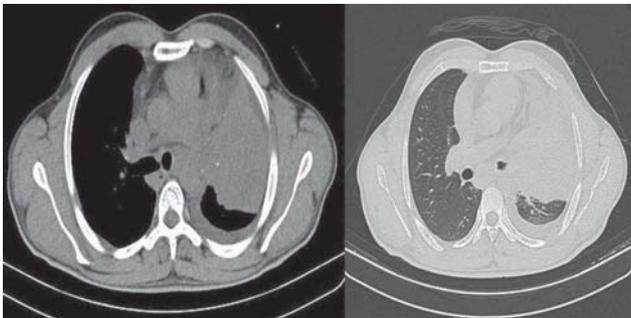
Computed tomography of thorax showing a large mass in the left upper lobe with minimal pleural effusion on the left.
